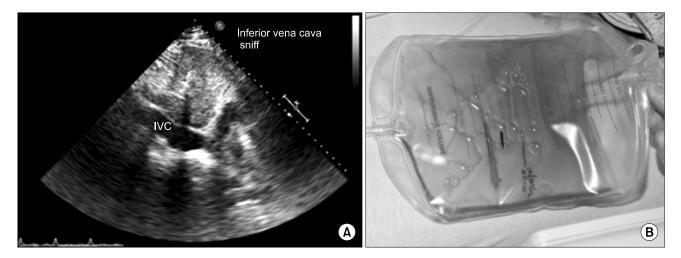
(A) Transthoracic echocardiogram showing dilated inferior vena cava (IVC), which is often seen with tamponade physiology. (B) Green pericardial fluid obtained after emergency pericardiocentesis that grew multiple microorganisms.
